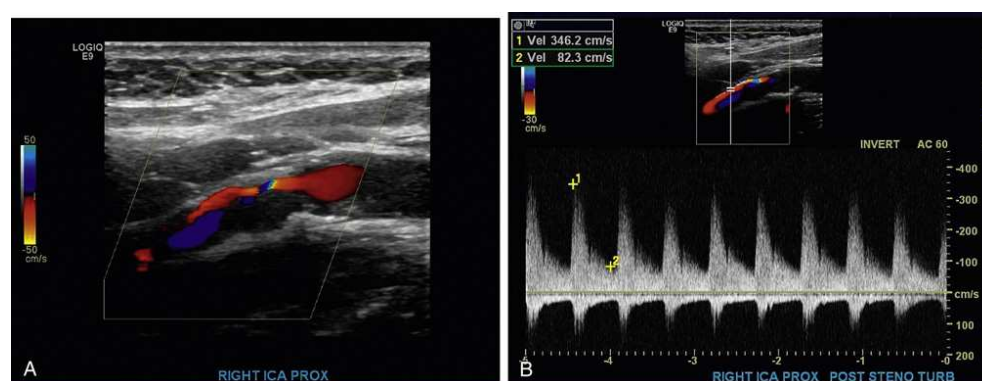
(A) Sagittal image of carotid artery with high-grade stenosis in proximal internal carotid artery. (B) Color Doppler and spectral analysis show increases in flow velocity in stenotic internal carotid artery.
